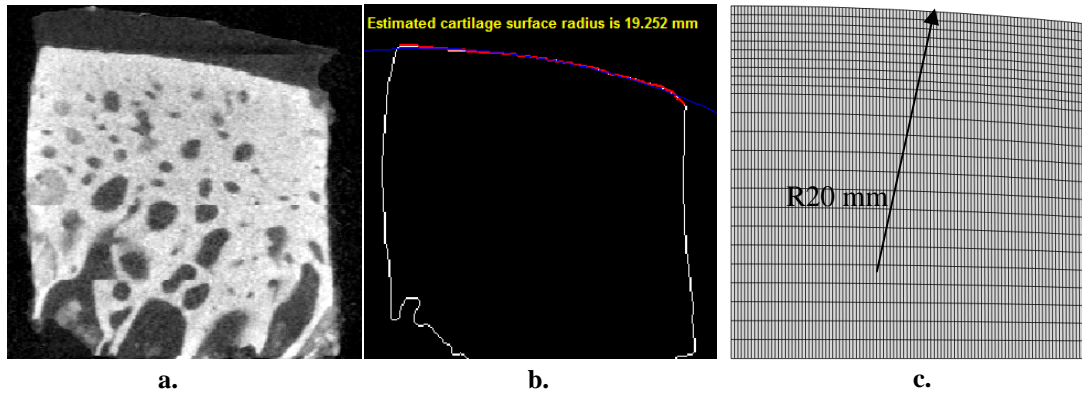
a. μ CT scan image of the most curvature cartilage pin, b. Measurement of the cartilage surface radius, c. Axisymmetric FE model of 20 mm radius with convex curve.
